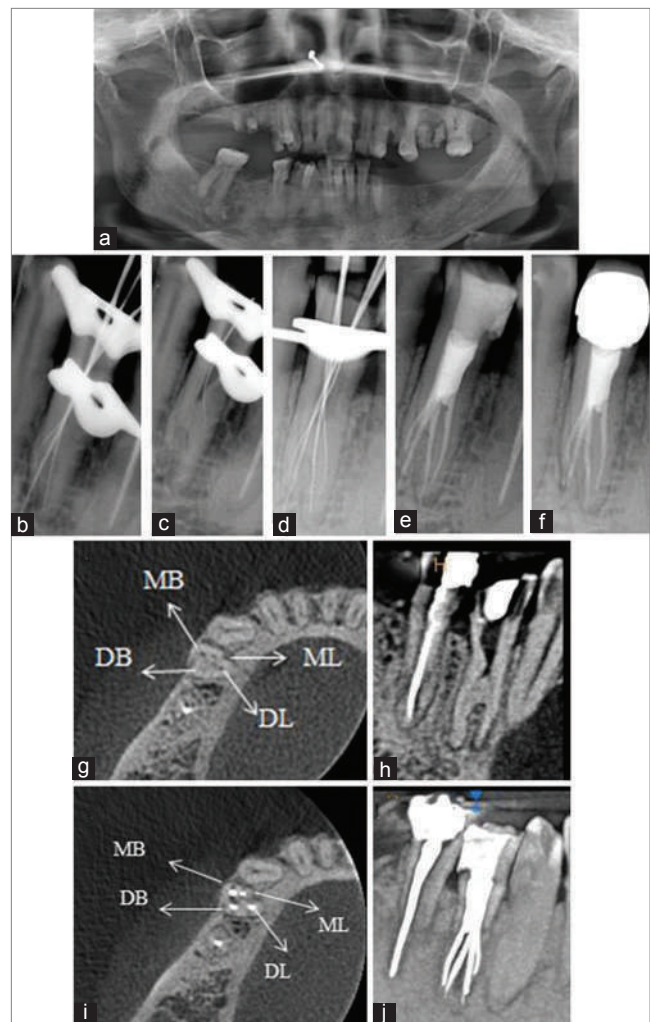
Mandibular right first premolar (#44): (a) Preoperative orthopantomograph. (b) Working length intraoral periapical radiograph, (c) Intraoral periapical radiograph reveals to have an extra fourth canal, (d) Working length intraoral periapical radiograph, (e) Postoperative intraoral periapical radiograph. (f) Postoperative intraoral periapical radiograph with crown, (g and h) Preoperative cone-beam computed tomography scan axial view and sagittal view, (i and j) Postoperative cone-beam computed tomography scan axial view and sagittal view
